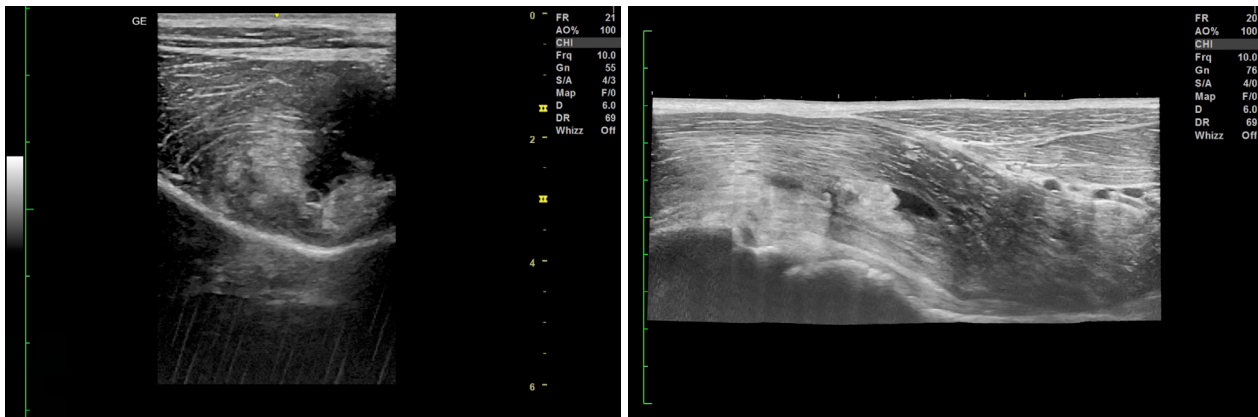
Ultrasound images compatible with an iliopsoas grade 2 myotendinous junction muscle injury. A – Transverse Plane; B – Longitudinal Plane;
